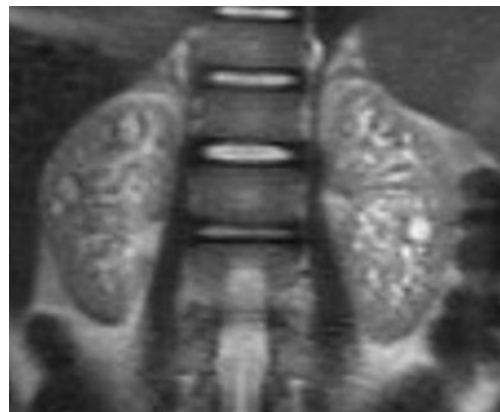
Coronal T2-W MRI of the kidneys
